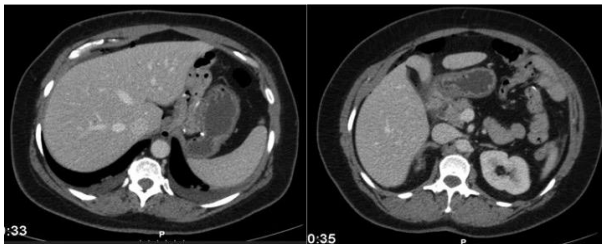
CT images of the patient showed anastomotic permeability without gastric dilatation and a small pneumoperitoneum.
